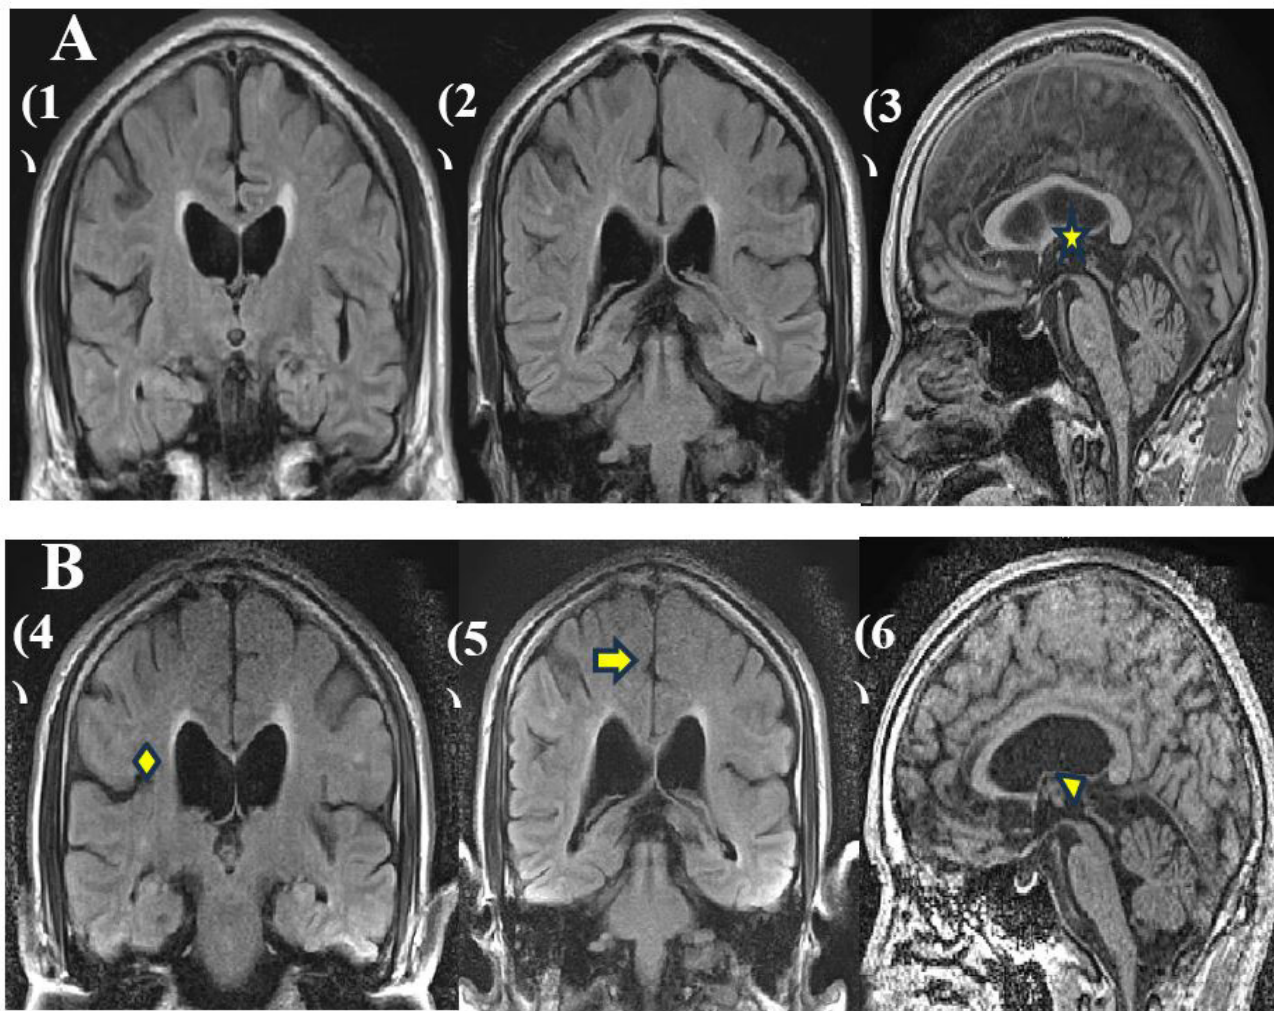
Brain Magnetic Resonance Imaging (MRI) of the brain.
